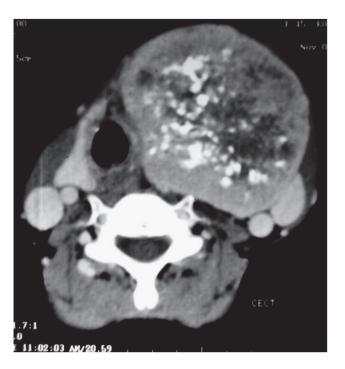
CT scan of neck showing well defined calcified mass lesion at left lobe of thyroid.
